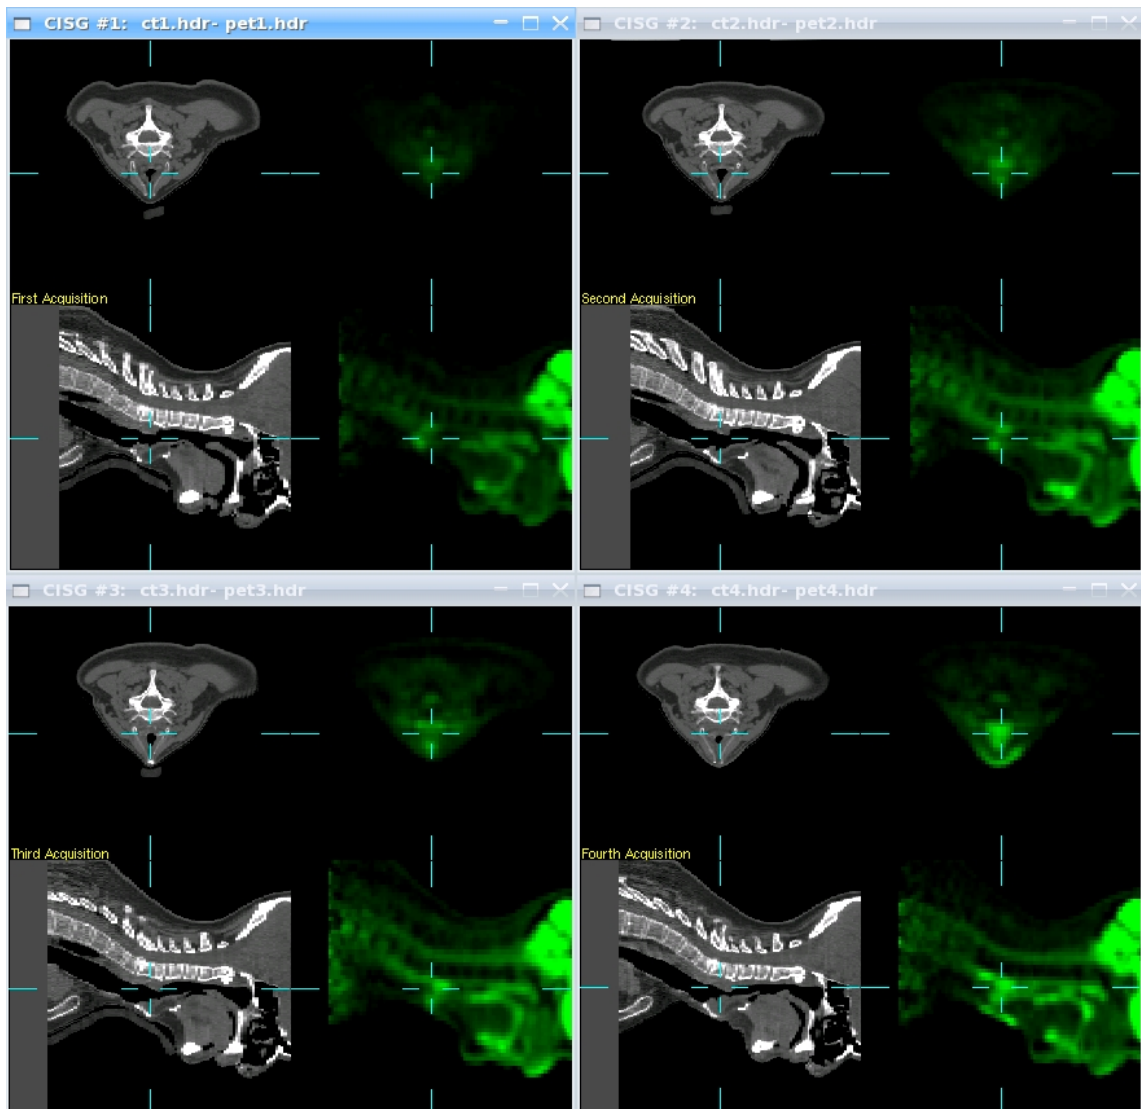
PET/CT acquisitions for patient 1. CT image in grey colourscale and PET image in green colourscale. Top left are pre-treatment images, then (clockwise) the first, third and second successive acquisitions from the study detailed in section 4.1.1.
